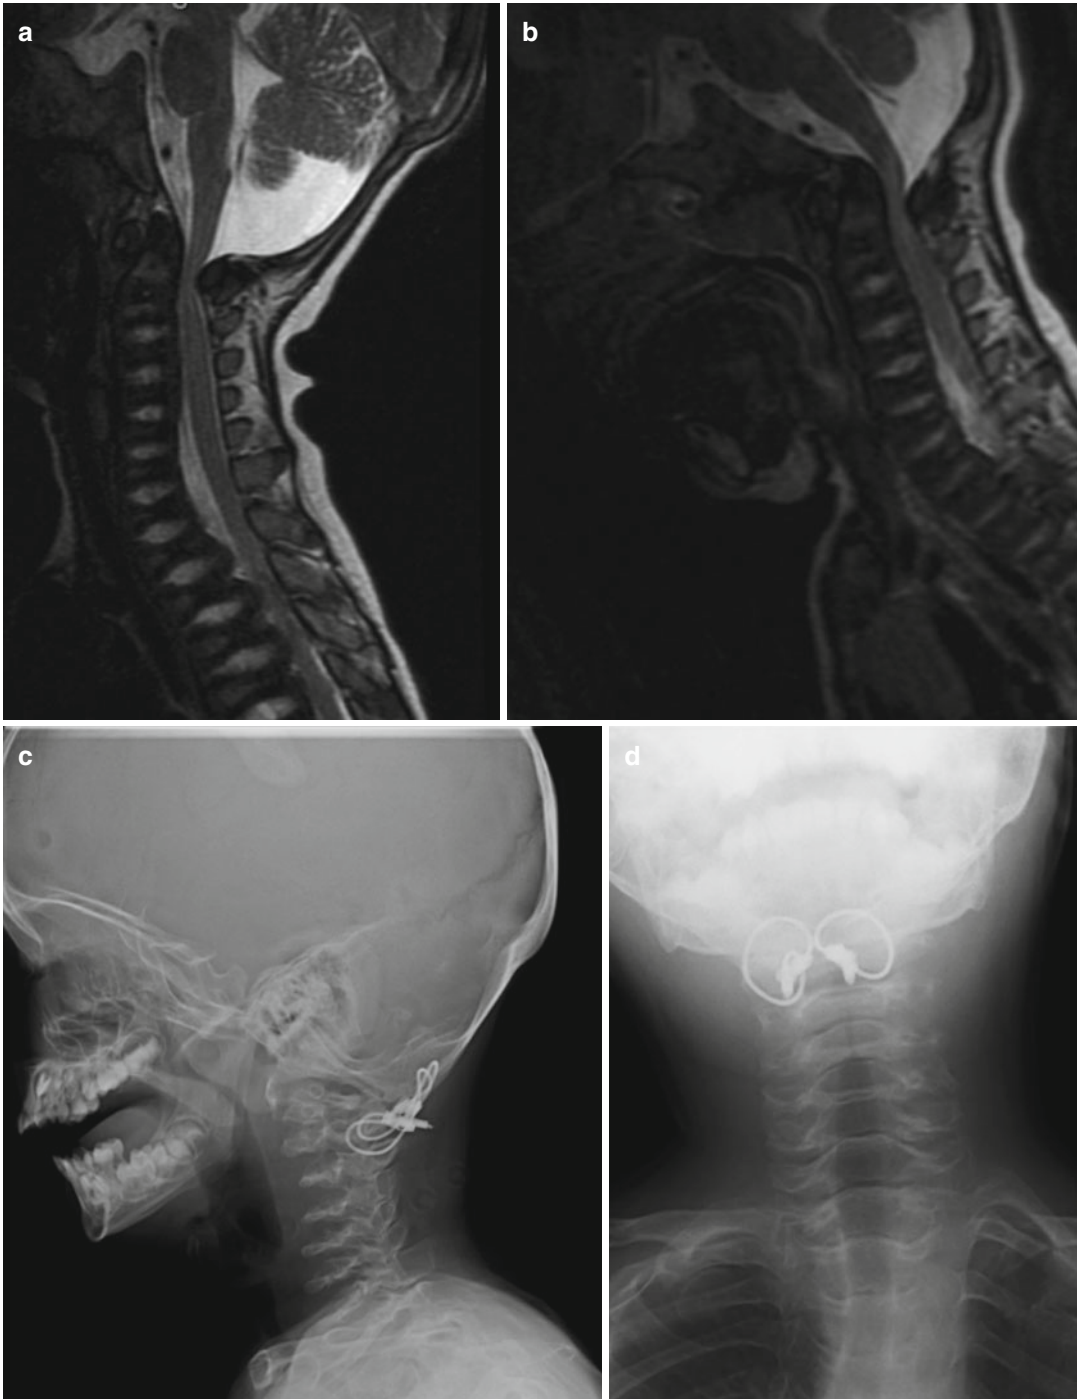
C1 stenosis without instability in metatropic dysplasia. MRI views in flexion (a) and extension (b). C1 laminectomy was performed. Stabilization was
